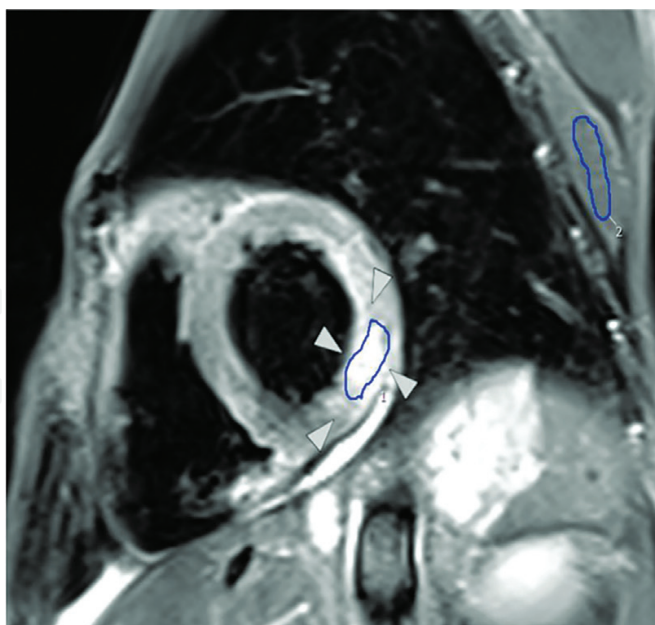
CMR T2-weighted short-tau inversion recovery image showing elevated myocardial: Skeletal muscle signal intensity ratio of the lateral wall (white arrows) in a patient with HIV-associated acute myocarditis. Regions of interest drawn in blue.
